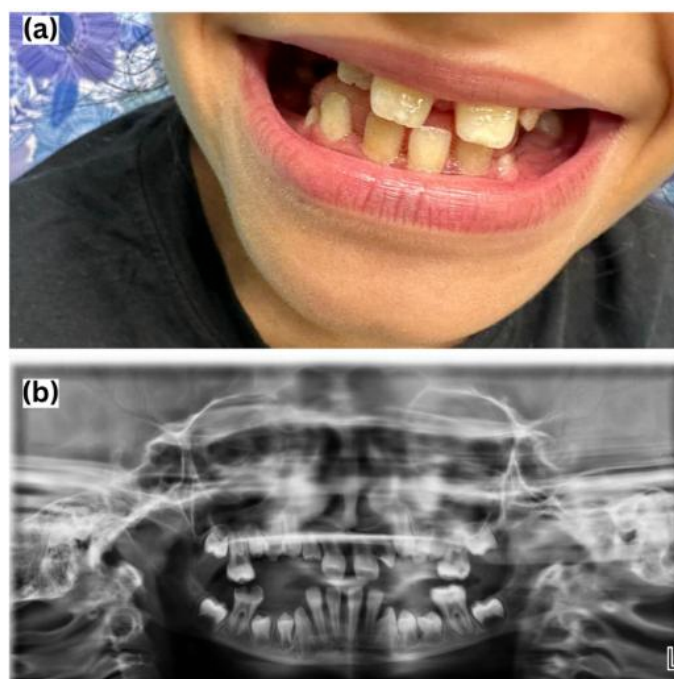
Extra-oral photograph (a) shows gingival inflammation with visible plaque accumulation, mixed dentition. The panoramic radiograph (b), revealed complete exfoliation of all primary teeth and demonstrated localized alveolar bone loss in lower lateral incisor and both mandibular molar (Furcation involvement in mandibular molars).
